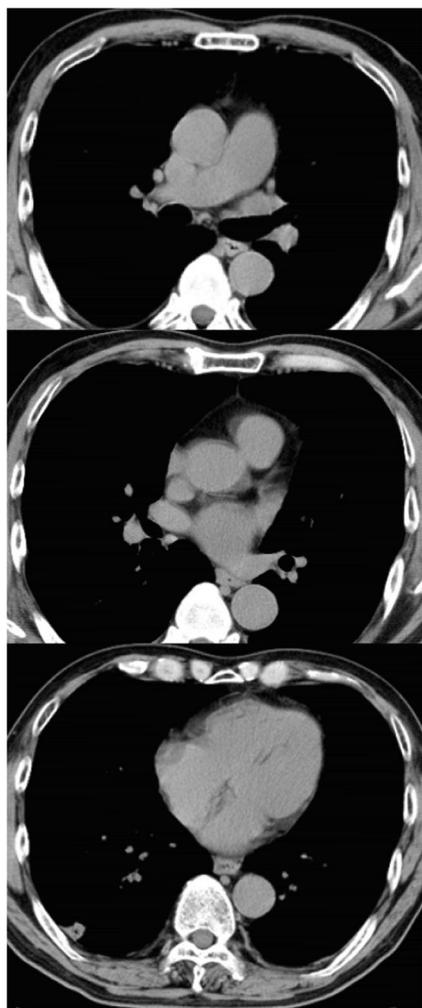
Chest CT demonstrated no abnormal mediastinal and hilar lymph node swelling. Chest CT also demonstrated no pleural effusion
